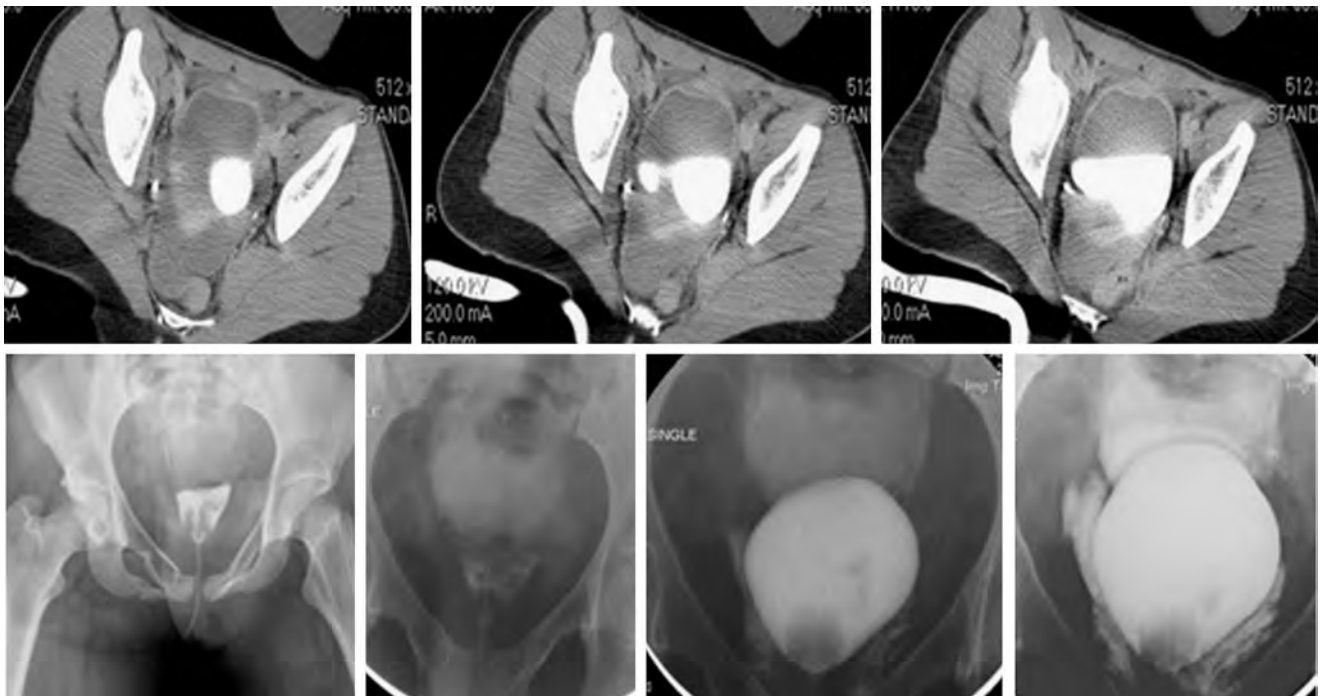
A 15-year-old girl with a pelvic fracture underwent a screening computed tomography scan that suggested a bladder injury, which was confirmed by contrast cystography. Note the extreme elevation of the bladder neck ("pie-in-the-sky") on the cystogram and clear demonstration of contrast medium collecting in the retroperitoneal space.
